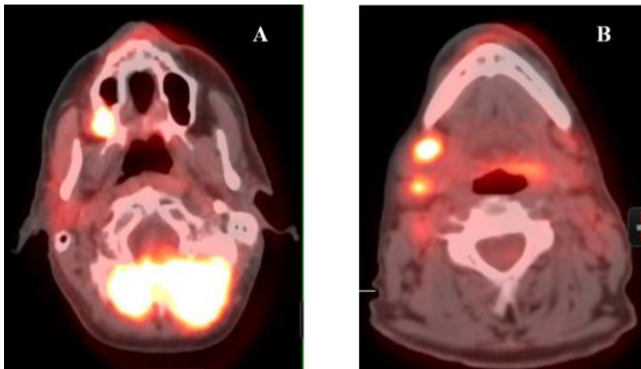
PET-CT showing increased SUV of the right posterior maxilla involving the right maxillary sinus (A). Additionally, there is increased SUV of right lateral neck nodes indicating metastatic disease (B).
